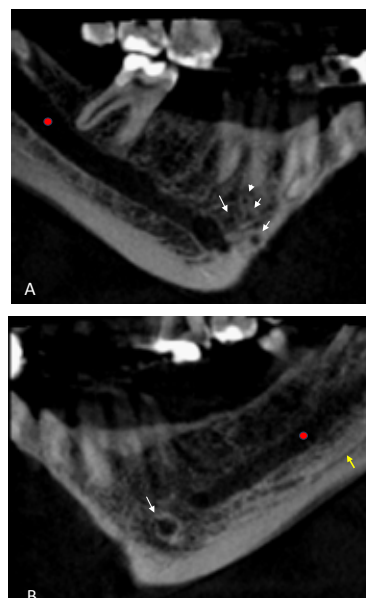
Sagittal section of the cbct scan with lateral to medial orientation. A showing right sided enlarged mandibular canal at the level of second molar (red dot) and multiple accessory mental foramina (white arrows) anterior to the main mental foramen. B showing the left sided mandibular canal (red dot) communicating with an accessory mandibular canal (yellow arrow) inferiorly upto the level of mental foramen, accessory mental foramen (white arrow).
